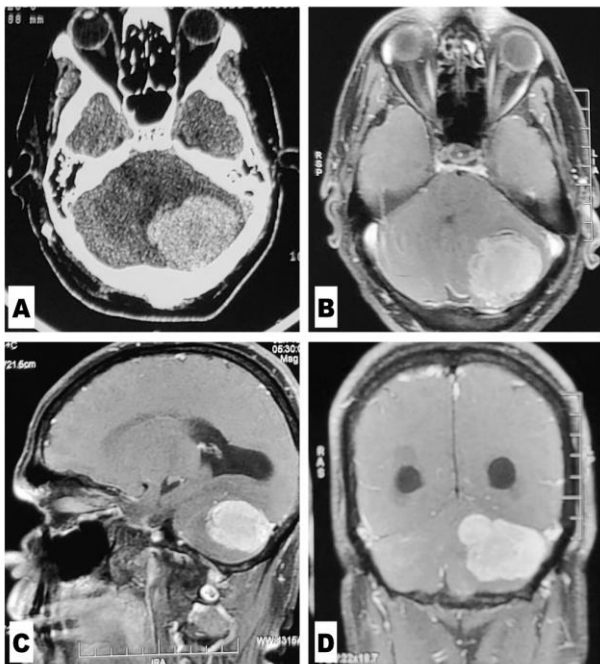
Preoperative CT Non-contrast (CT) and Contrast-Enhanced MRI images. (A) CT images revealed a hyperdense lesion in the left cerebellar hemisphere with associated perilesional edema. (B) Axial view, contrast-enhanced T1WI MRI. (C) Sagittal view, contrast-enhanced T1WI MRI. (D) Coronal view, contrast-enhanced T1WI MRI. Contrast-enhanced MRI brain revealed a 4.5cm x 5cm x 3.5cm intra-axial heterogeneous mass lesion in the left cerebellar hemisphere which was hyperintense on T1 and hypointense on T2 with mass effect and perilesional edema.
